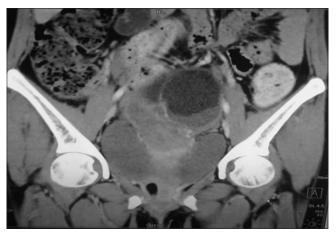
A contrast-enhanced computed tomography revealed a well-defined lesion seen in the left adnexal region and extending in the pouch of Douglas
